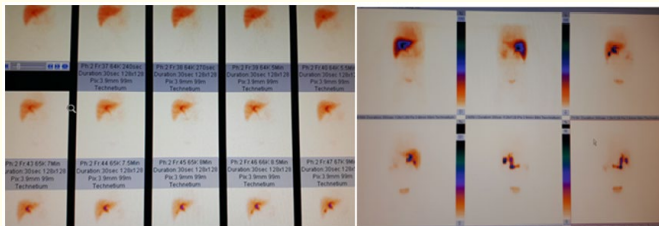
Cholescintigraphy demonstrates the primary underlying pathophysiology of chronic cholecystitis, that is, obstruction of the cystic duct, and thus the 99mTc-HIDA radiopharmaceutical cannot enter the gallbladder, include delayed bile-to-bowel transit with normal filling of the gall bladder. The presence of intestinal transit before filling the gall bladder after the first hour of images suggests cholecystitis chronic acalculose [11].
